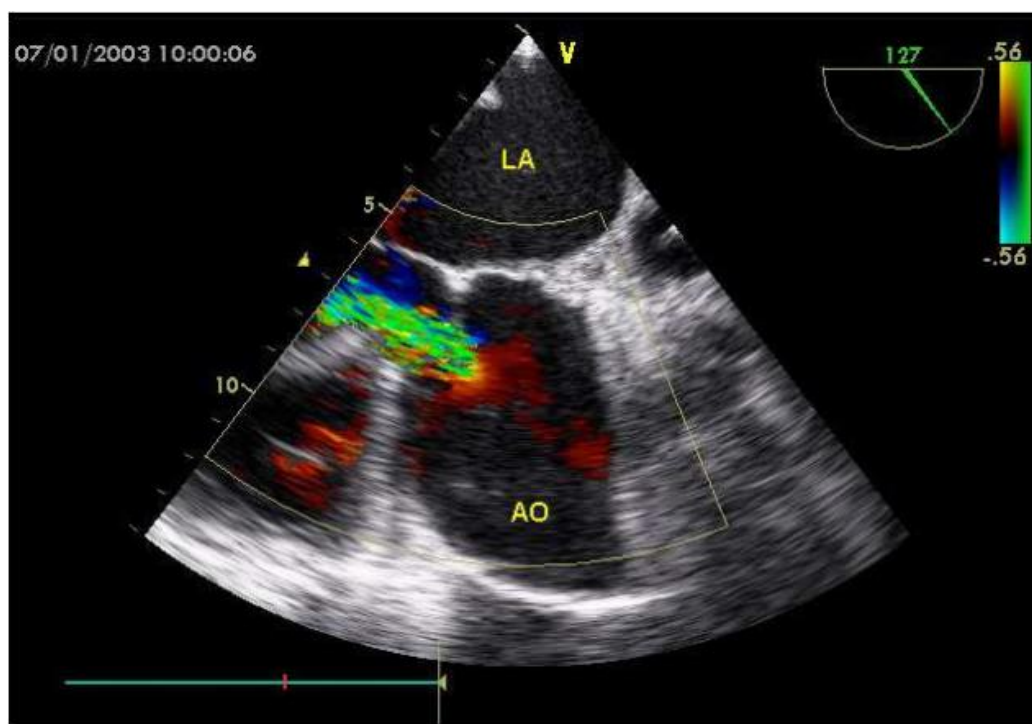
Doppler imaging of the regurgitant jet characteristic of aortic insufficiency (Čanádyová et al., 2011).
